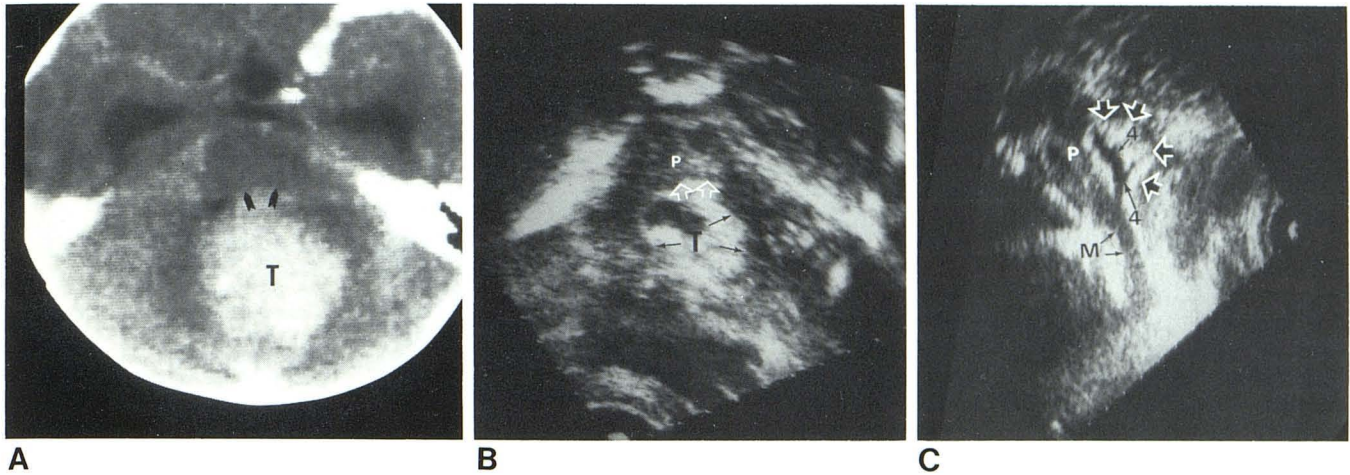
Cerebellar tumor. A, CT of posterior fossa. Anterior part of tumor (T) is embedded in pons (arrowheads). B, Sonogram through occipital craniotomy, axial plane. Tumor (T) extension clearly visualized (black arrows).
